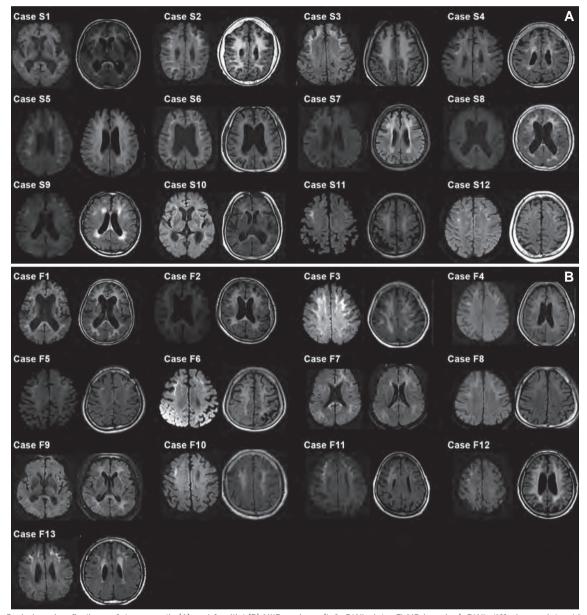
Brain imaging findings of the sporadic (A) and familial (B) NIID patients (left, DWI; right, FLAIR imaging). DWI, diffusion-weighted imaging; FLAIR, fluid-attenuated inversion-recovery; NIID, neuronal intranuclear inclusion disease.
